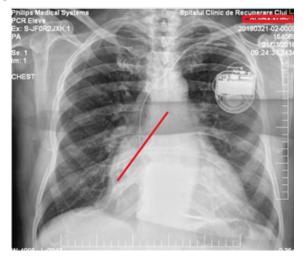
Standard thoracic radiograph obtained in the posteroanterior projection. The distance between the lateral wall of the atrium and the left bronchi's can be measured. It is over 70mm in case of a dilated LA.
